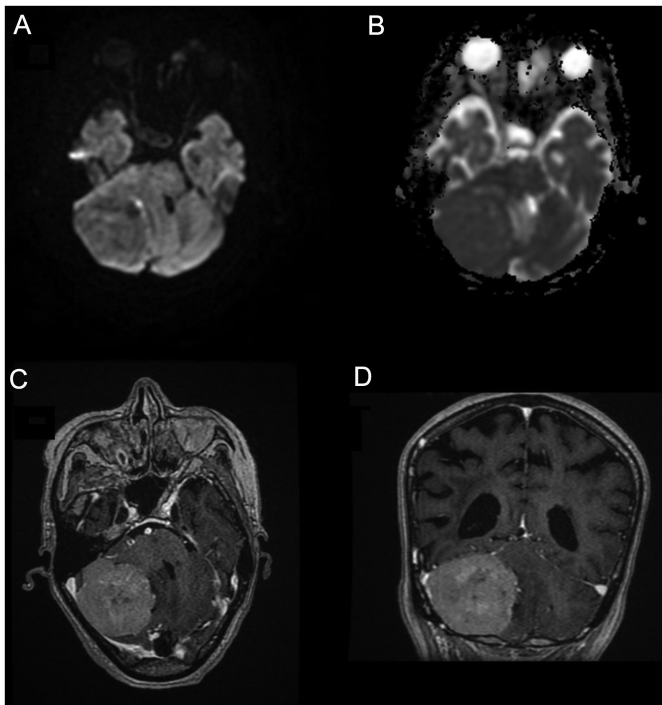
In diffusion-weighted and ADC MR images of a 77-year-old woman, a well-defined extra-axial mass at the right infratentorial region, measuring 5.8 cm × 4.6 cm was detected (A, B). It has a broad base to the dura. The mass also demonstrates homogeneous contrast enhancement (C, D). ADC, apparent diffusion coefficient; MR, magnetic resonance.
